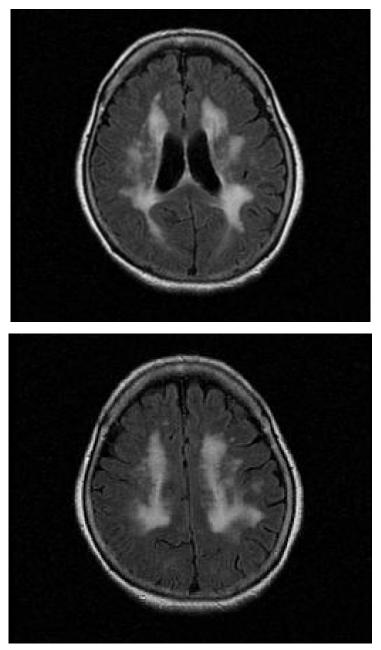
White matter hyperintensities on brain magnetic resonance imaging from a 73 year old female with advanced cognitive impairment (score 18 on MMSE). Extensive hyperintensities can be seen in deep white matter, especially in periventricular region. She is under medication for hypertension and hyperlipidemia
